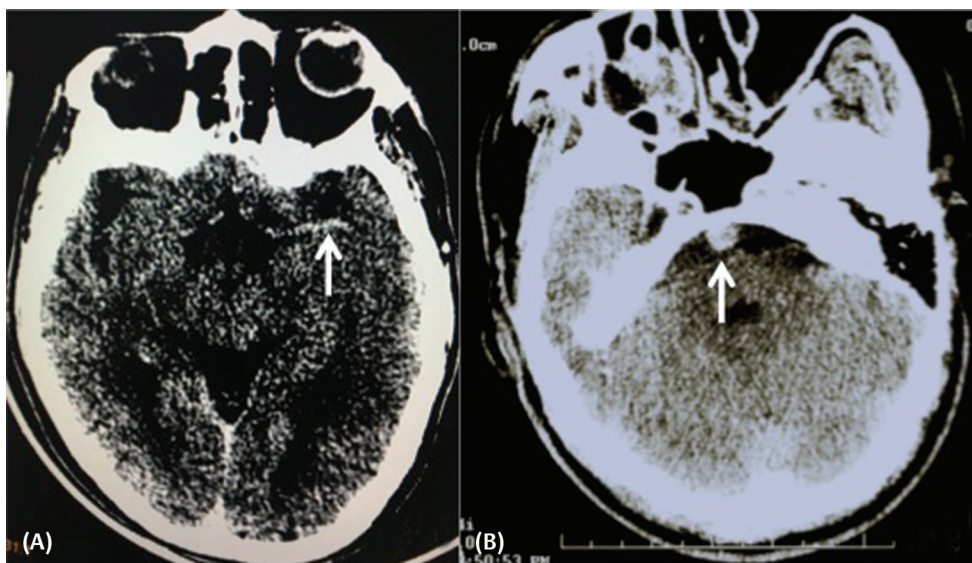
Axial noncontrast computed tomography (CT) brain sections showing hyperdense arteries (arrows) in two different patients of left middle cerebral artery (MCA) thrombus (A) and basilar thrombus (B). Note the expanded hyperdense artery.
